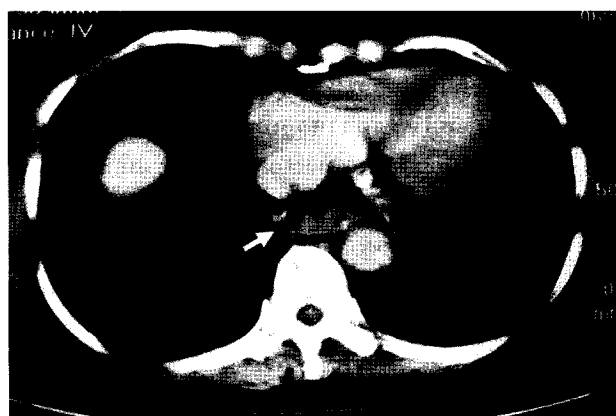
Thoracic CT with enhancement showing a water density mass without enhancement extending from carina to esophagogastric junction of esophagus (arrow)
